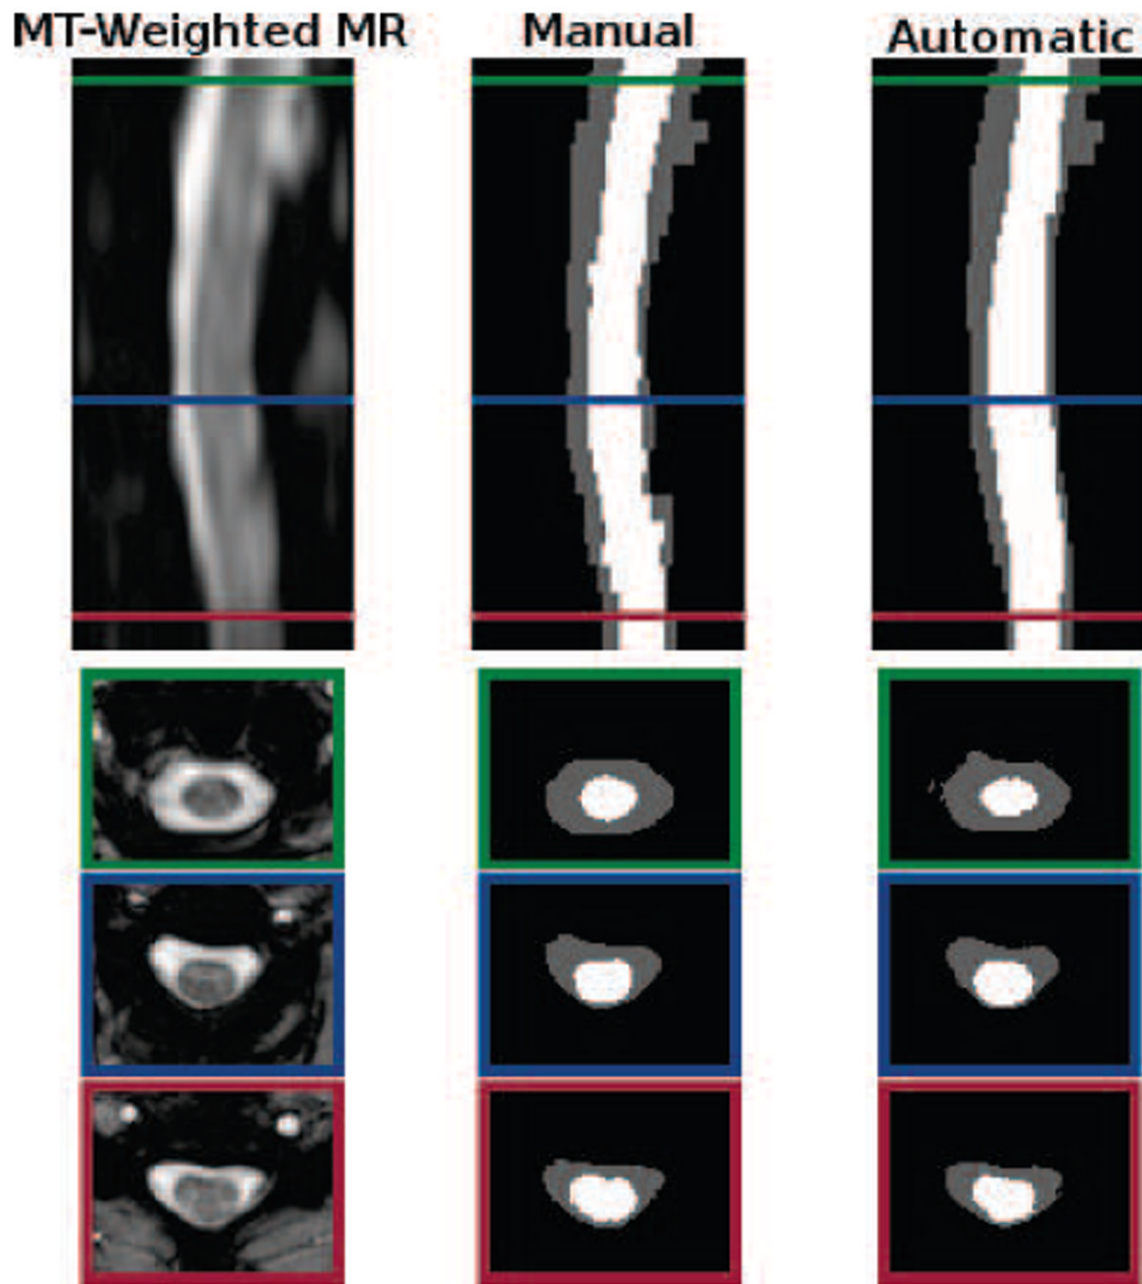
Cropped example of a MT-prepared T2*-weighted MRI segmentation by a human rater in comparison to the result from our algorithm. Shown are one sagittal and three axial views. The colored border around the axial slices denote the respective cross-section within the sagittal image. The Dice coefficient between the shown manual and automatic segmentations are 0.91 for the spinal cord (white) and 0.86 for the CSF (gray).
